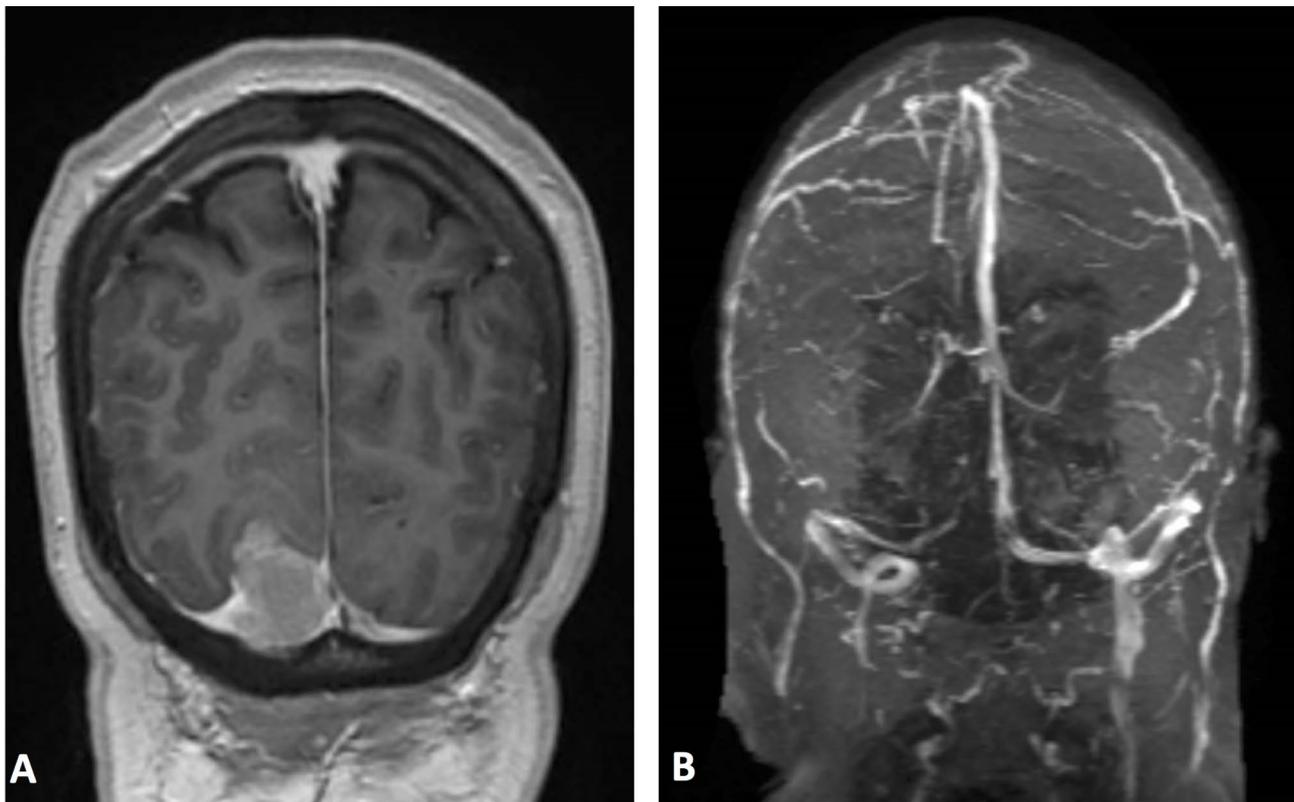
Case number 2. MRI examination: space-occupying lesion in the occipital lobe (A). MRV examination: compression of the sigmoid and transverse venous sinus (B)
